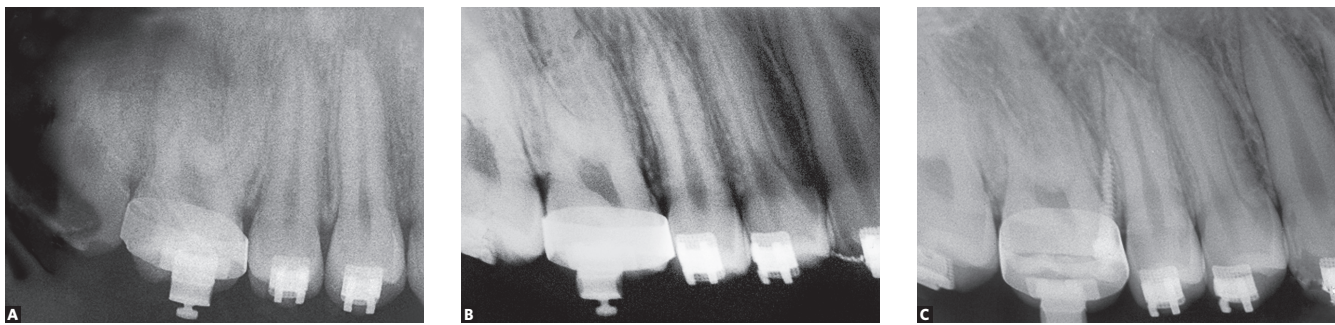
Periapical radiographs. A) Reduced space between #15 and 16 roots; B) Enlargement of space between roots after orthodontic bends were performed in the arch; C) Mini-implant placement.
